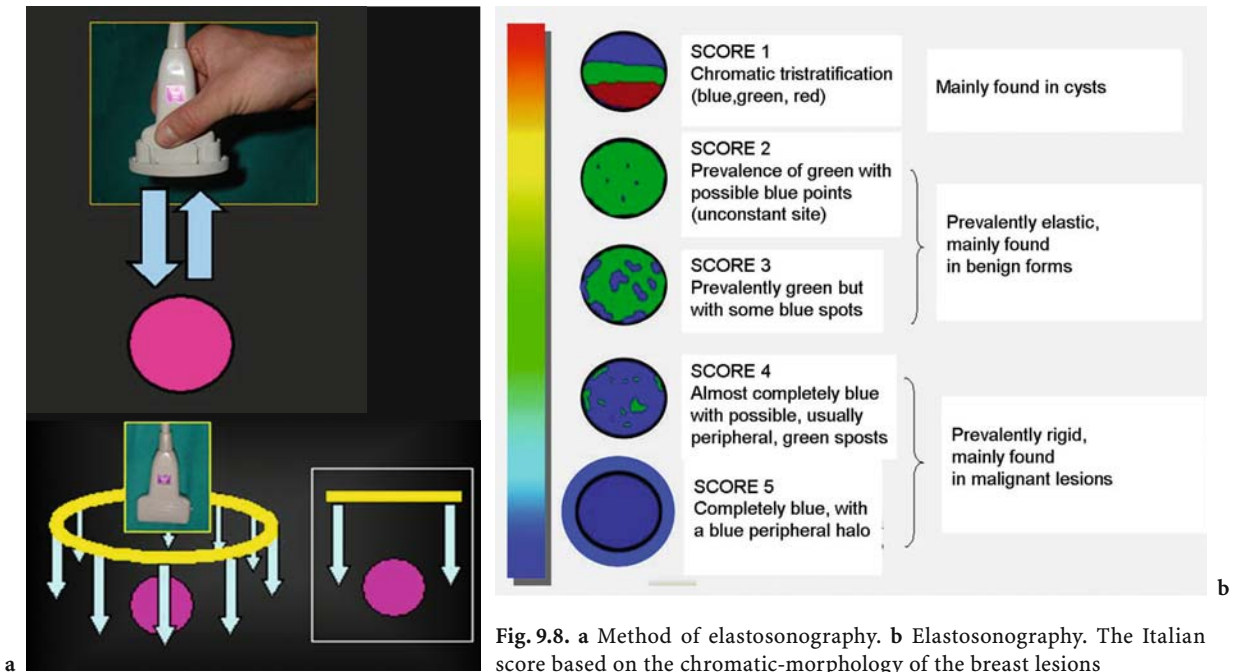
a Method of elastosonography. b Elastosonography. The Italian score based on the chromatic-morphology of the breast lesions
